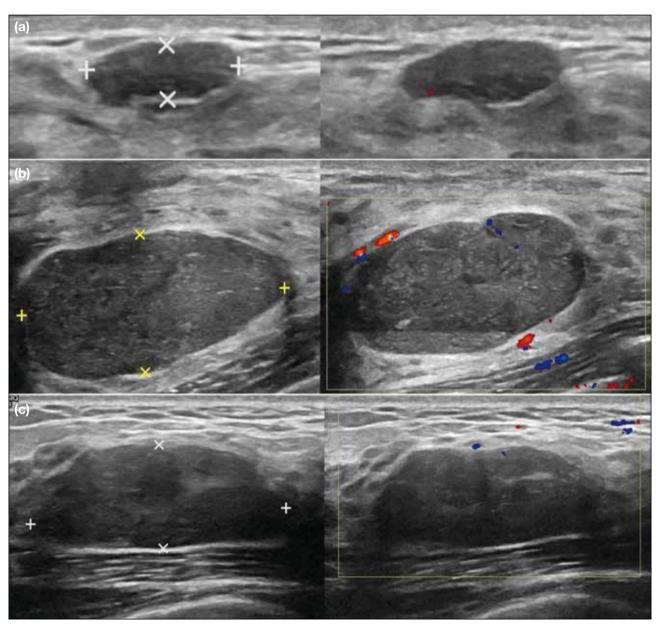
A 17-year-old female presented with bilateral self-palpated breast masses. Initial ultrasound (US) showed multiple hypoechoic lesions in both breasts (not shown). A follow-up US was performed 1 year later. (a) In the left breast at 6 o'clock position 2 cm from the nipple, an oval parallel circumscribed and hypoechoic lesion with mild vascularity on colour Doppler US was stable in size. (b) In the left breast at 6 o'clock position in the subareolar region, an oval parallel circumscribed and hypoechoic lesion showed interval increase in size, with mild vascularity on colour Doppler US. (c) In the right breast at 12 o'clock position, an oval parallel microlobulated and hypoechoic lesion also showed interval enlargement, without increased Doppler flow. Surgical excision was performed. Pathology showed fibroadenoma and a benign phyllodes tumour in the left breast, and pseudoangiomatous stromal hyperplasia (PASH) in the right breast, corresponding with findings on US. This highlights the occasional similar appearances of fibroadenoma, phyllodes tumour, and PASH.
